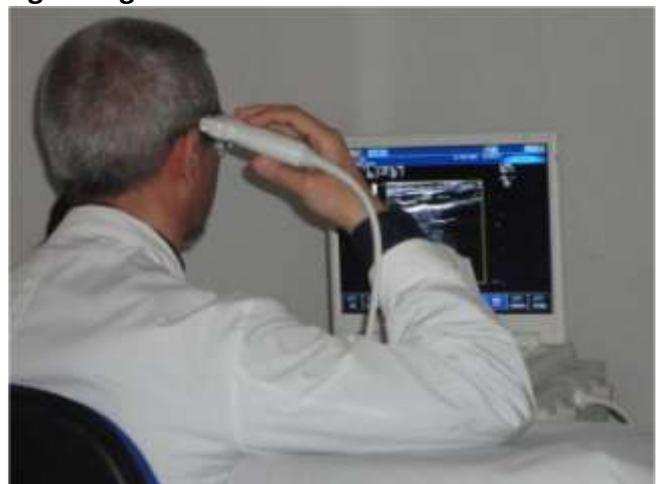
The operator (M.R.) applying the probe to his right temporal region. Sitting in front of the ultrasound imaging machine, the operator is able
